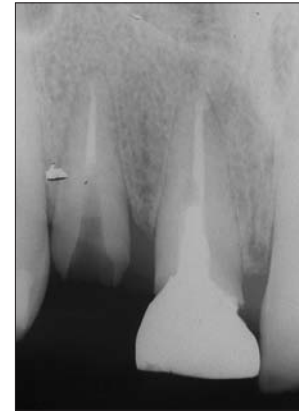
Radiograph of maxillary right lateral incisor before treatment.
